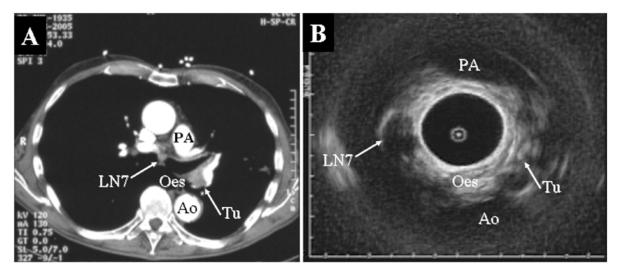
(A) CT image of a patient with a centrally located left lung tumour (Tu) and non-enlarged subcarinal nodes (LN7). (B) Endobronchial ultrasound visualises the pulmonary artery (PA) interiorly, the oesophagus (Oes) and aorta (Ao) posterior, and the tumour (Tu) laterally of the bronchus. The subcarinal adenopathy (LN7) is well localised for a safe puncture.
